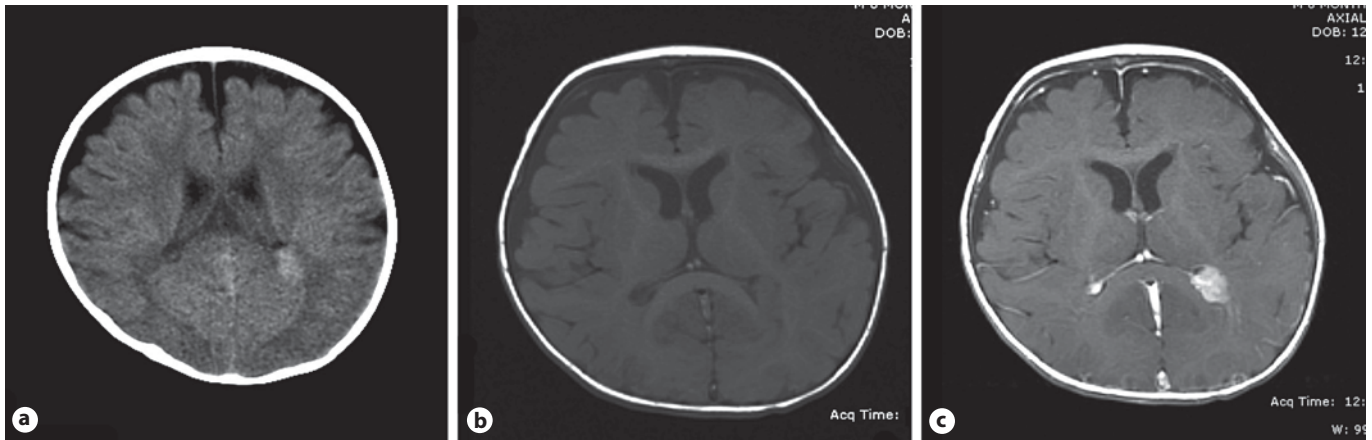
Axial radiographic images of proband at time of presentation showing enhancing left ventricular mass. a CT. b T₁-weighted MRI without contrast. c T₁-weighted MRI with contrast.
